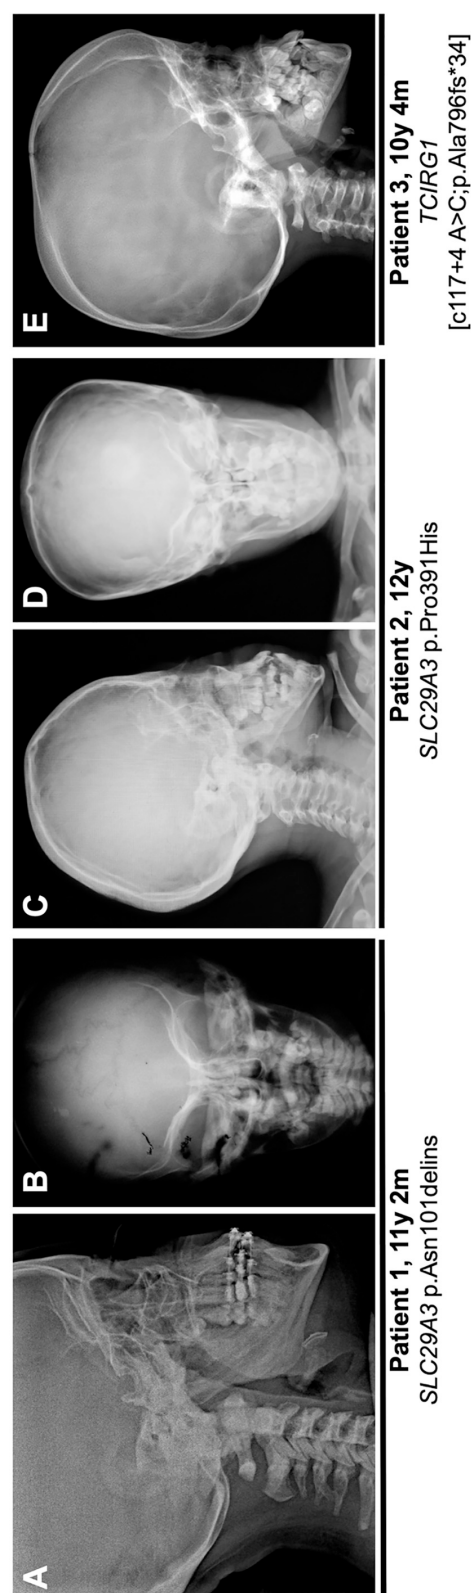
Cranial radiographs of Patient 1 (A, B) and Patient 2 (C, D), and Patient 3 (E) in occipito-frontal (A, C, E), anterior-posterior (B, D), and lateral (A, C, E) exposure. In Patient 1, osteosclerosis of the skull base is revealed (A), but there is no clear evidence for calvarial thickening (B). Patient 2 shows a flat occiput and mild calvarial thickening (C, D). The skull base is mildly sclerotic. The most pronounced calvarial thickening is seen in Patient 3 (E), but sclerosis of the skull base is also rather mild.
